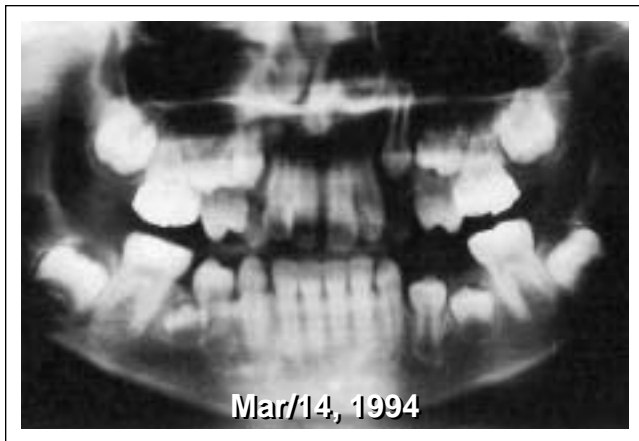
Panoramic radiograph. The significant delay of the lower right second premolar bud in relation to its counterpart makes it difficult to predict its likelihood to erupt.
